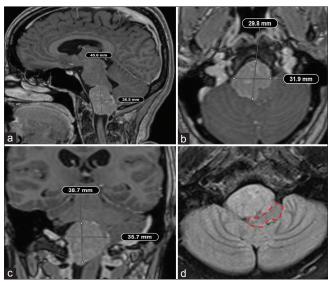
Head magnetic resonance imaging evidence large anterolateral foramen magnum mass with homogeneous enhancement of contrast in (a) sagittal, (b) axial, and (c) coronal views. (d) Note the important posterolateral displacement of brainstem (red traced lines).
